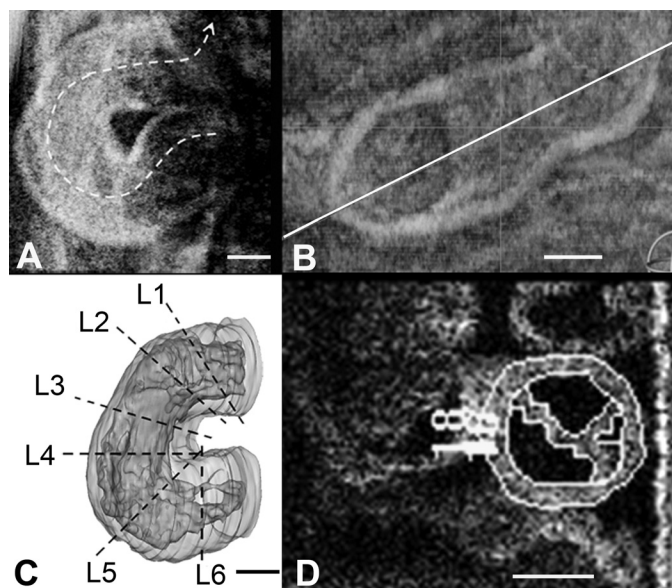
The embryonic heart as captured in real time and under physiological conditions with optical coherence tomography (OCT). A: the dashed white line shows the direction of blood flow on a digitally reconstructed OCT radiograph. B: for all 15 volumes analyzed, the placement of the midcoronal plane (white line) was the same. C: three-dimensional (3D) reconstruction of Hamburger and Hamilton (HH) stage 13 heart depicts endocardium (Endo) in dark gray, and myocardium (Myo) is transparent in light gray. Six cross-sectional cuts [levels 1–6 (L1–L6)] were defined perpendicular to blood flow. D: cross-sectional area measurements of the outer Myo area, endocardial lumen area, and cardiac jelly (CJ) area were performed with MetaMorph 6.1. The outlines are shown in white. Number 18 on figure identifies frame that was used. Magnification bars in all panels = 100 μm .
